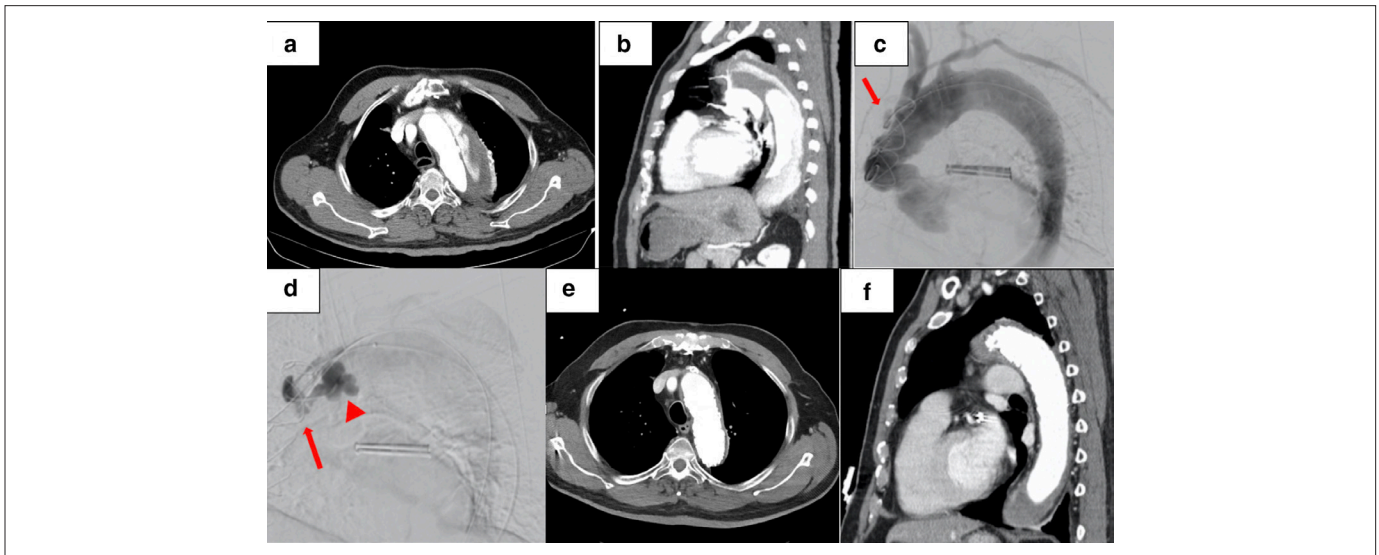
Preoperative and postoperative computed tomography (CT) and intraoperative angiography. (a–b) Preoperative CT shows a dissected aneurysmal descending aorta. There is a contrast in the false lumen of the aortic arch and the descending aorta. (c) Intraoperative angiography shows angiogram of the true lumen. A small entry tear is seen in the aortic arch (red arrow). (d) Angiogram from the false lumen revealed a narrow entry tear in the aortic arch (red arrow) and the flow going into a pocket extending along the aortic arch (red triangle). The blood was also flowing through this entry tear to the aneurysmal false lumen in the descending aorta. The neck of the pocket was plugged with Amplatzer vascular plug II. (e–f) CT at 2-year follow-up showed completely thrombosed false lumen of the descending aorta.
